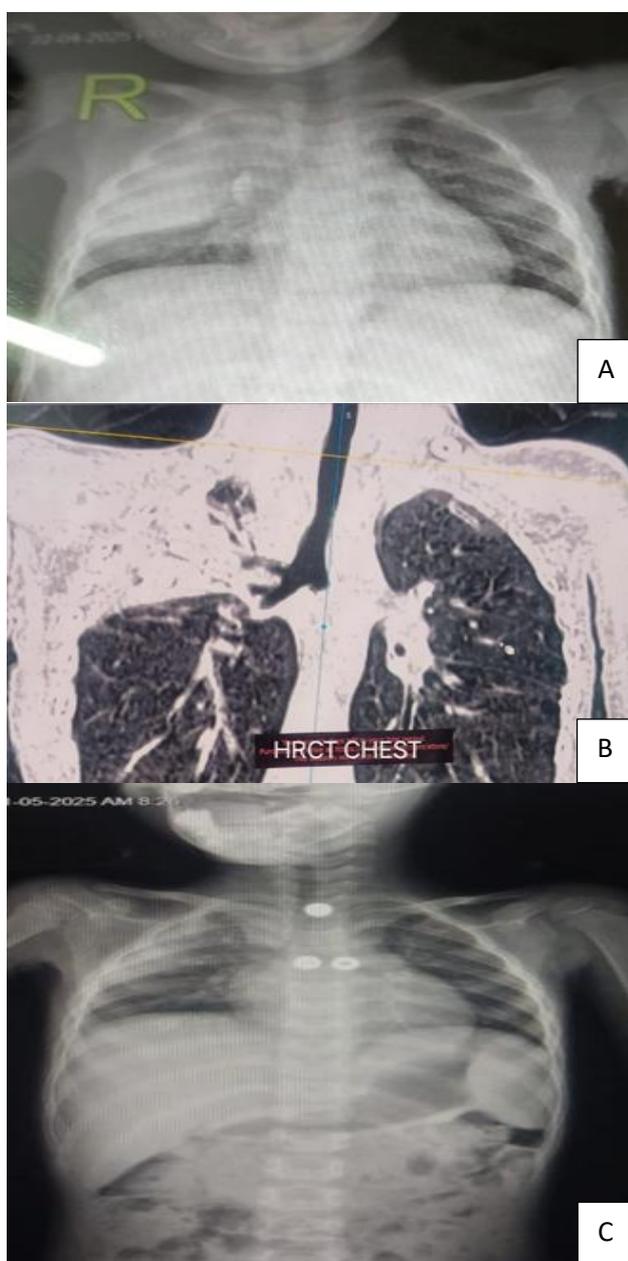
(A-C): HRCT chest.
